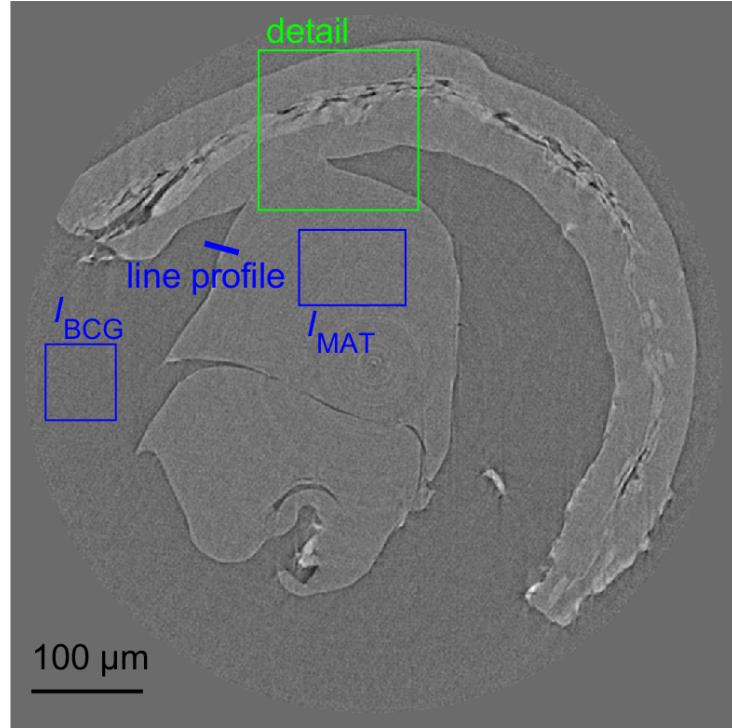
CT slice of the PEDT with highlighted areas for image evaluation.
